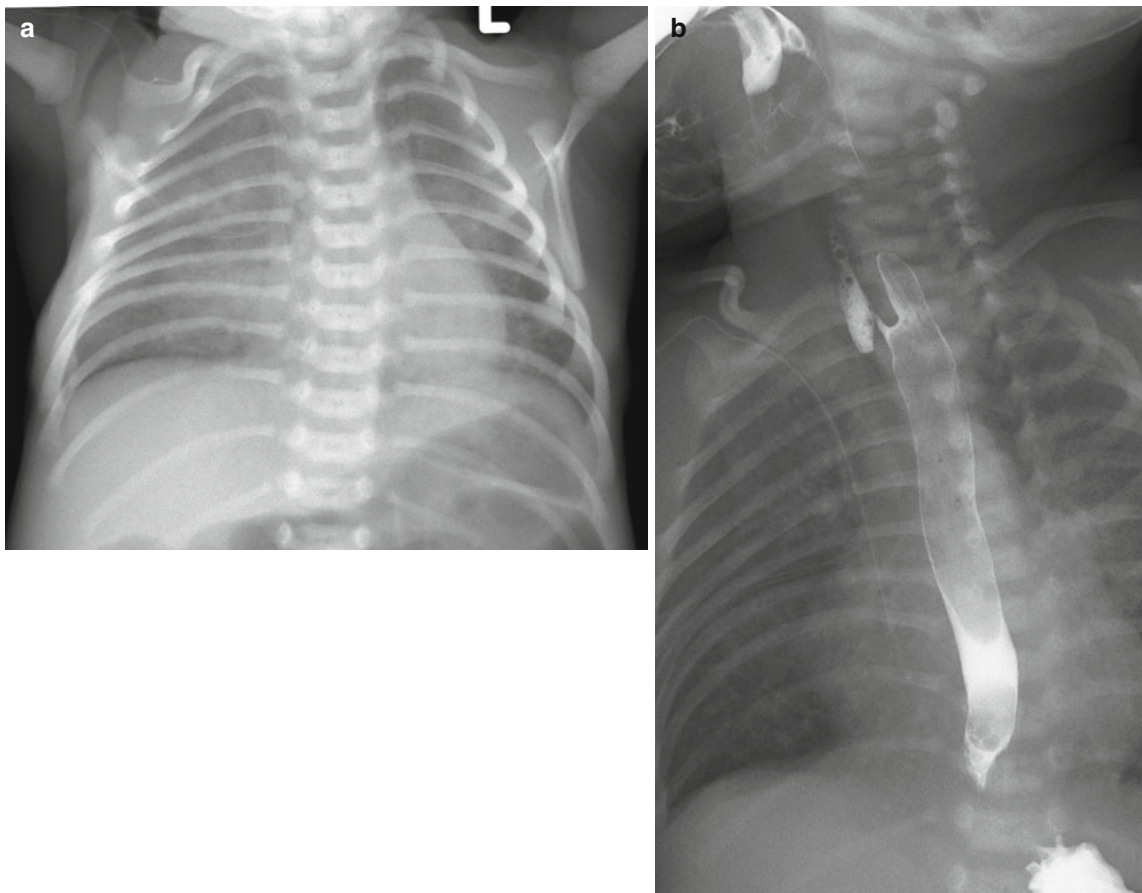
H-type tracheoesophageal fistula in a 12-day-old neonate.* (a) Chest radiograph shows infiltration in the right lung, which is gradually aggravated after birth. (b) Lateral view of esophagogram confirms
